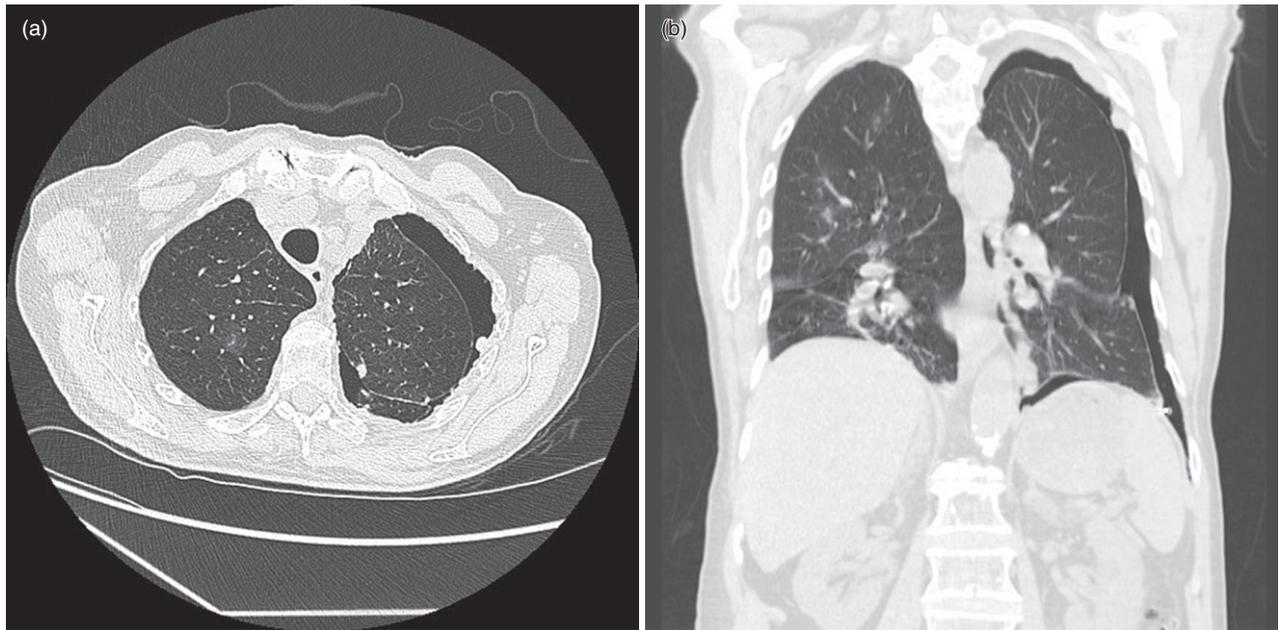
Computed tomography thorax (axial and coronal view) shows trapped lung in a patient with malignant pleural effusion. The left lung did not fully re-expand and precluded pleurodesis despite complete drainage of effusion via an intercostal catheter.
